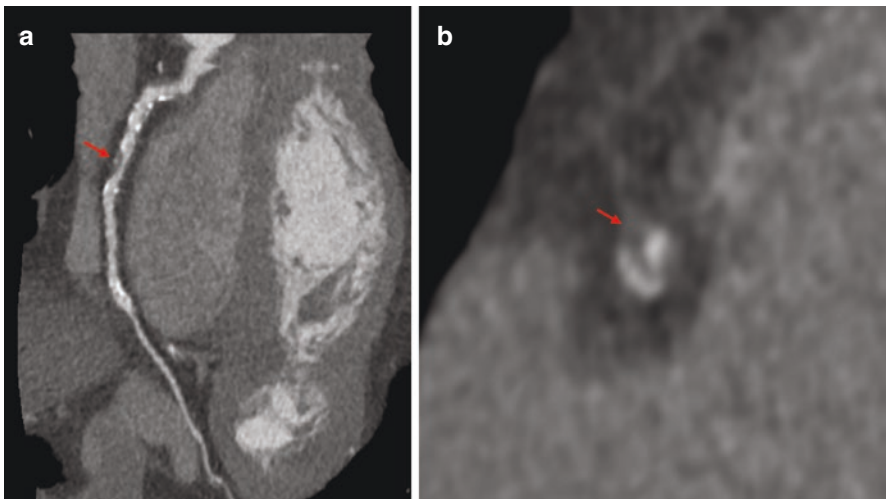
Coronary CT angiography demonstrates mixed coronary plaque (red arrow) (a) Curved multi-planar image showing mixed plaque with noncalcified, soft, lipid-rich plaque and calcified plaque in the proximal right coronary artery (red arrow) with severe stenosis. (b) Cross section of axial image showing mixed plaque with noncalcified, soft, lipid-rich plaque surrounding calcified plaque in proximal right coronary artery (red arrow)
